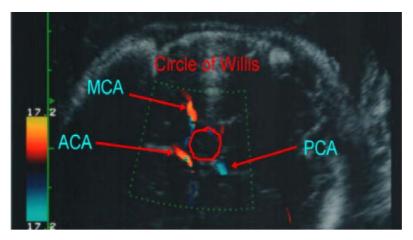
Color Doppler imaging of the Circle of Willis with the intracranial vessels. MCA: Middle cerebral artery, ACA: anterior cerebral artery, and PCA: posterior cerebral artery.
